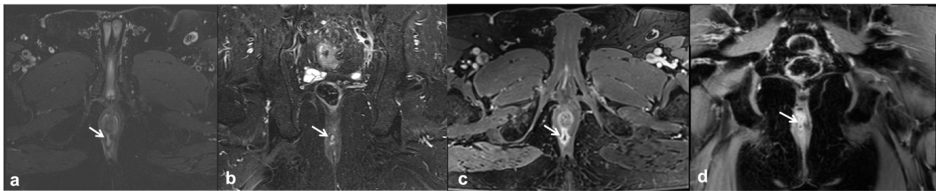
Intersphincteric fistula, 64 year old male patient, 1.5T perianal MR imaging with i.v. contrast media injection. a. axial T2W FS image, hyperintense linear fistula tract (arrow) at 6 o'clock position, b. coronal T2W FS image, hyperintense fistula tract (arrow) c. axial postcontrast T1W FS image, peripheral rim enhancement (arrow) and anal canal opening is best distinguished in this sequence, d. coronal postcontrast T1W FS image, fistula tract with peripheral hyperintense rim enhancement (arrow). W:weighted, FS: fat saturated
